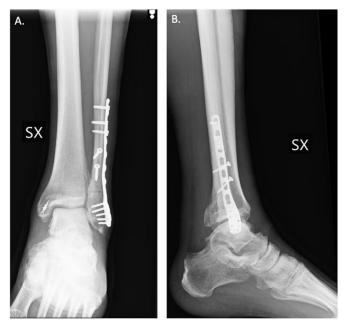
One-year follow-up X-ray assessment with anteroposterior (A) and lateral (B) view of the left ankle after open reduction internal fixation and DL repair with 5 mm anchor. Imaging demonstrated no development of ankle osteoarthritis and excellent mortise restoration.
